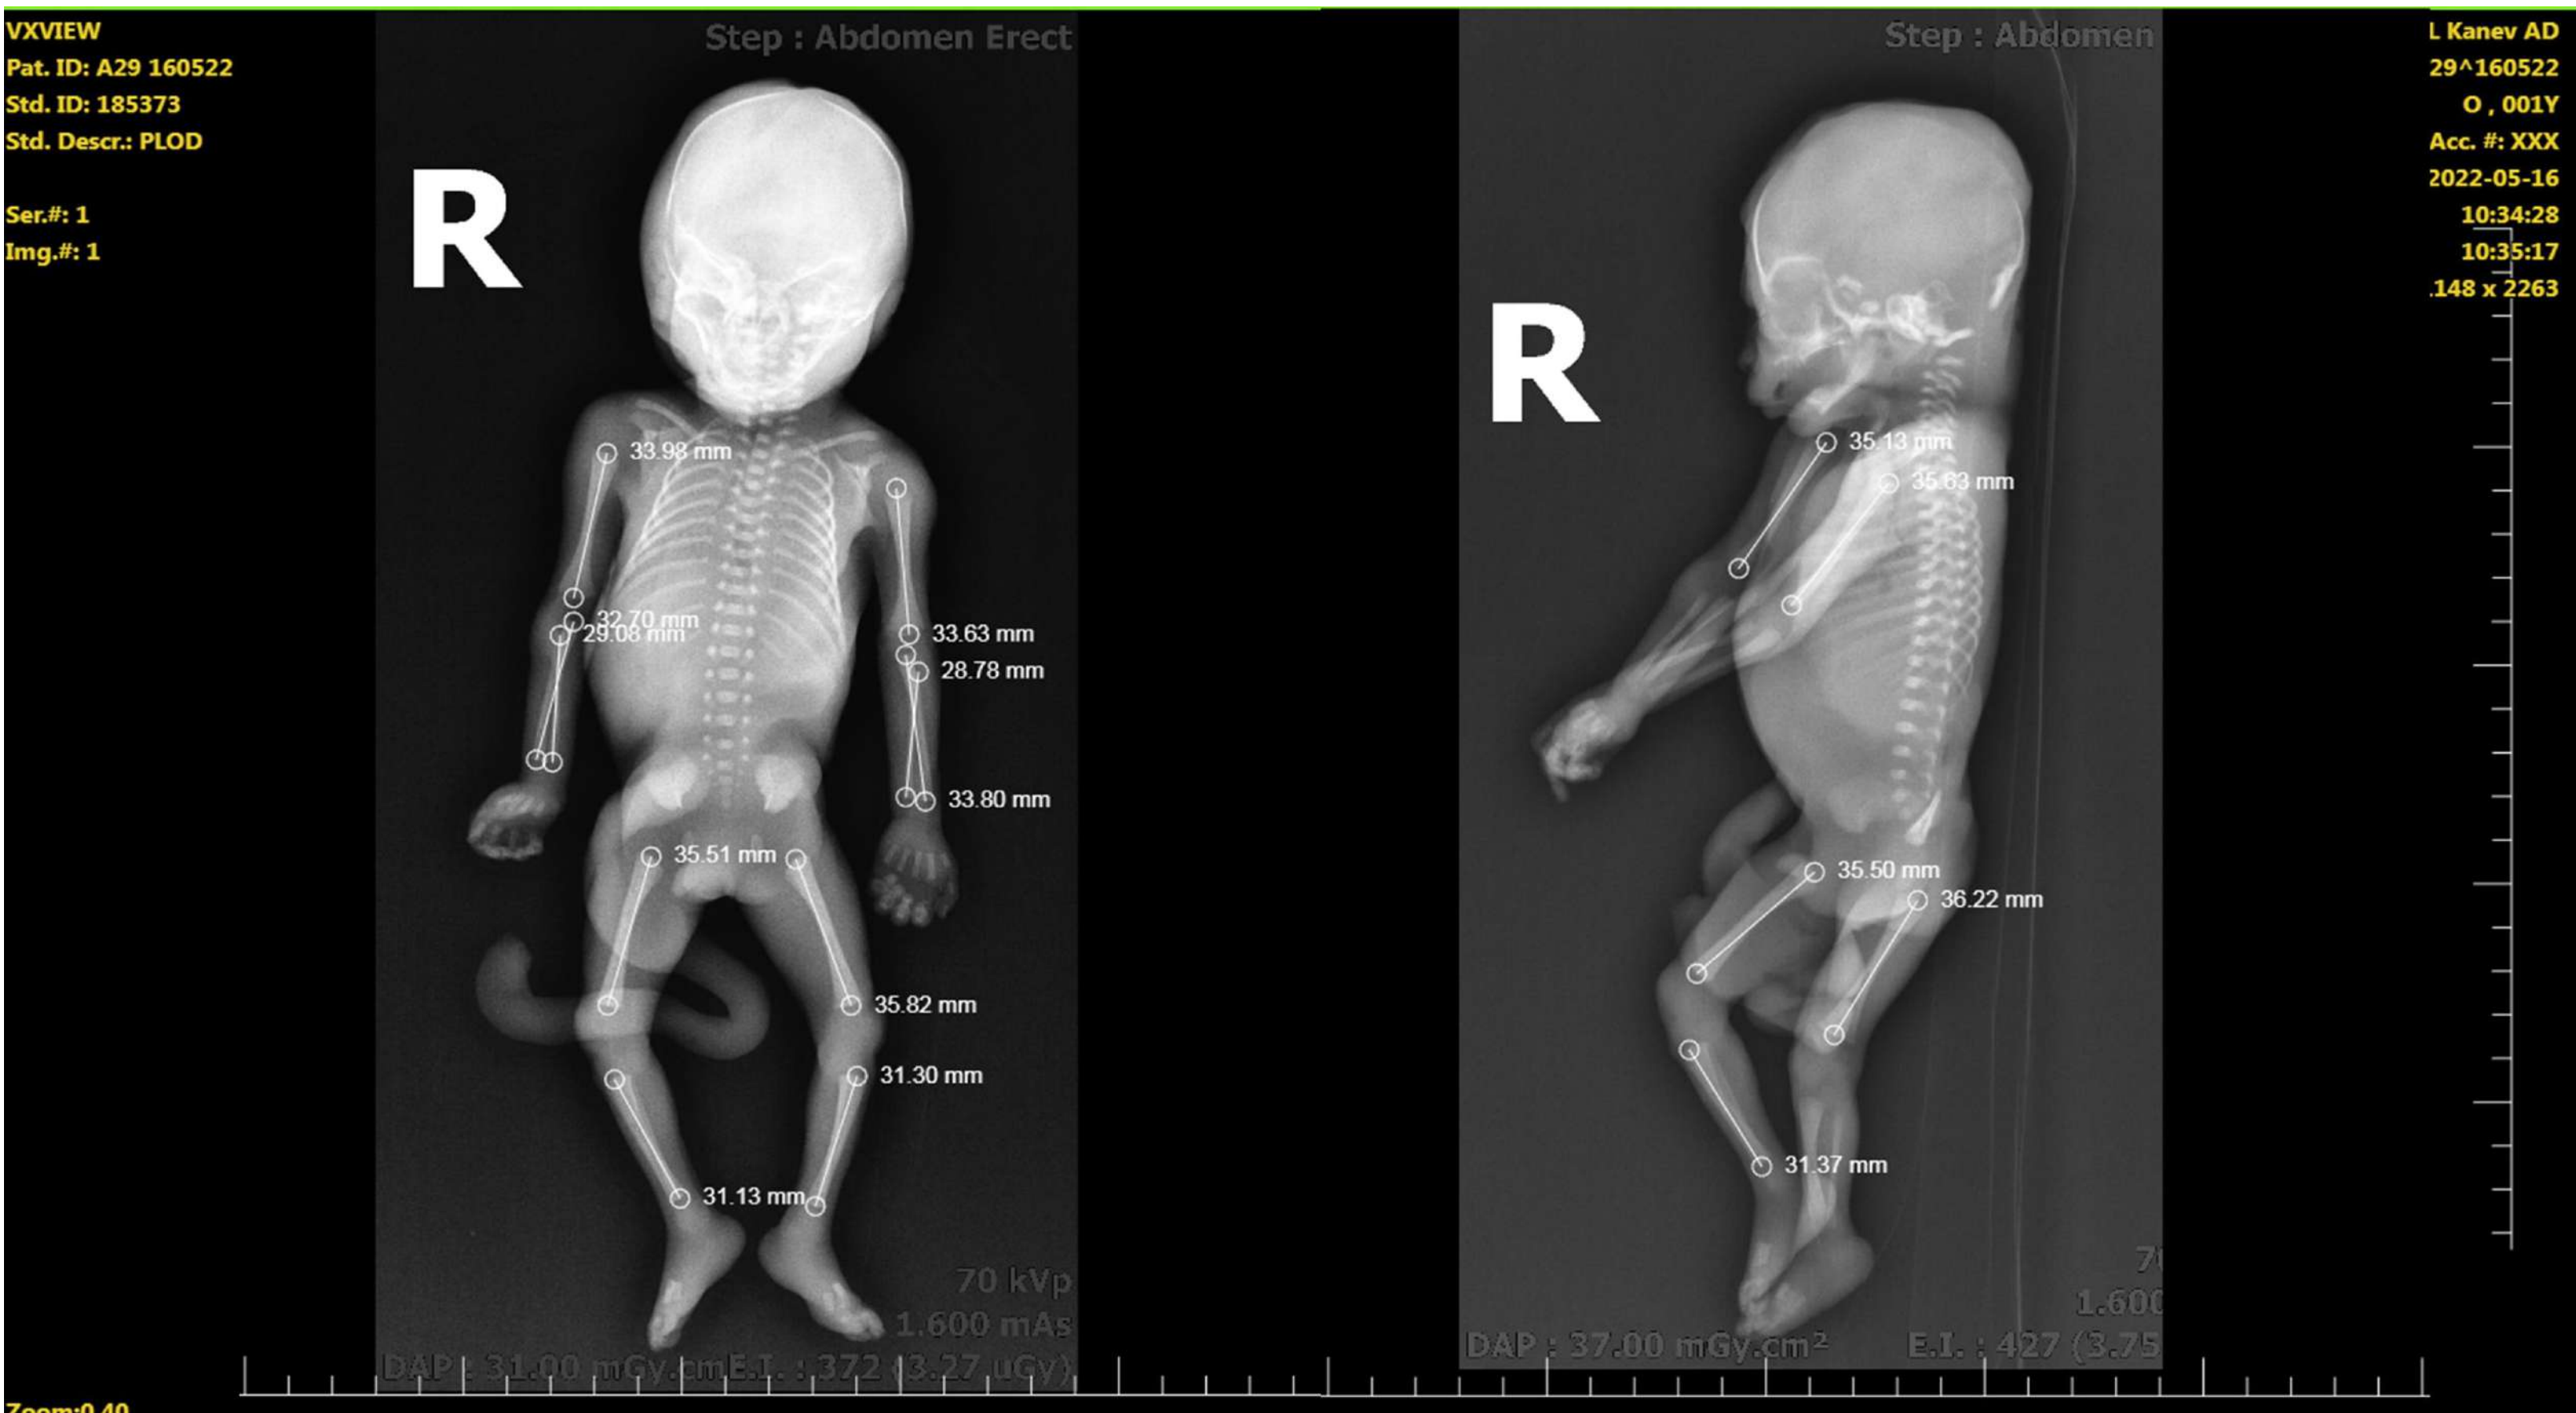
Radiographs of the fetus: Ossification of the facial bones, frontal and occipital bones, as well as the base of the cranium; long bones, ribs and vertebral bodies, which are closer to the arches; teeth are visible; calcaneus is hardly visible with very low density; there is no ossification of the sternum and the pubic bones. Based on the assessment of the ossification, the gestational age is 21 g.w., and based on the metrical assessment of the skeleton, - 20 – 23 g.w. All analysis was in accordance with *Fetal Radiology – A Diagnostic Atlas, 2nd Edt. 2010, Springer*
